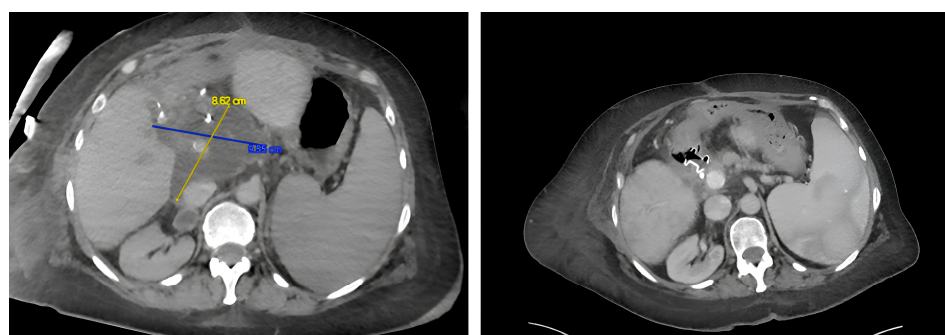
Biloma on MRI and after endoscopic ultrasound-guided (EUS) drainage.
